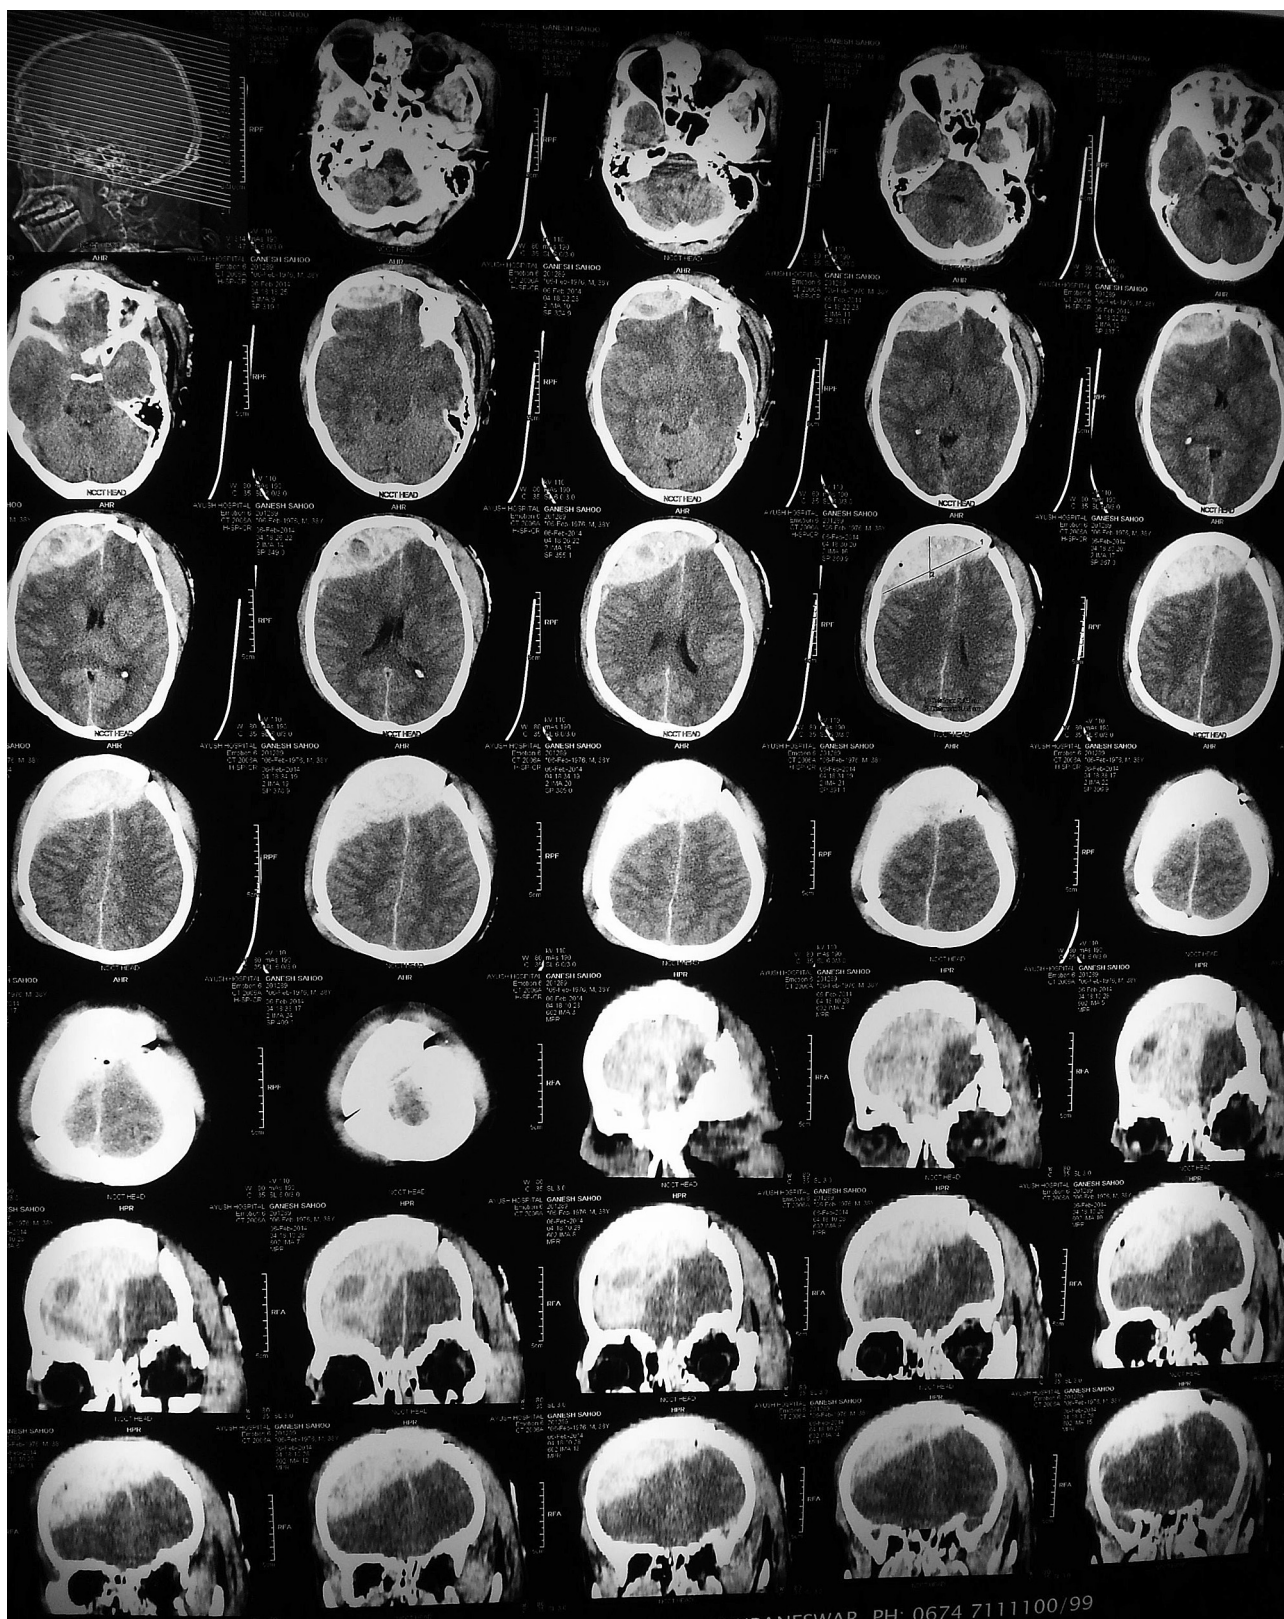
Non-contrast computed tomography of head shows a large extradural vertex hematoma extending from bilateral subfrontal region to bilateral frontoparietal convexity crossing the midline causing compression of cerebral hemispheres.
